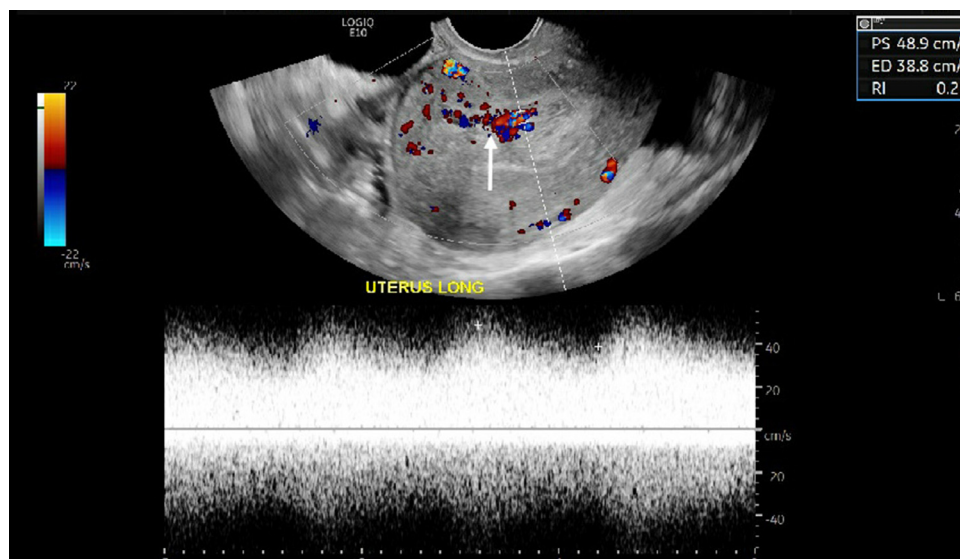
Spectral Doppler study images showing high PSV in tortuous vessels.
